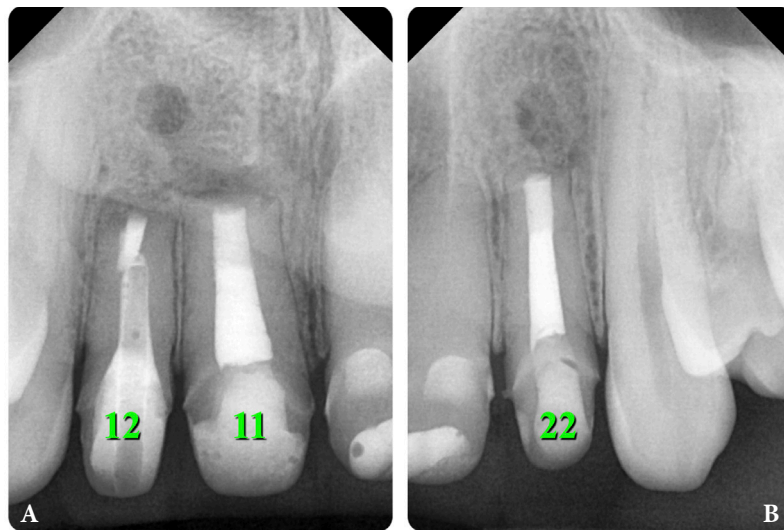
X-ray (A, B) and CBCT (Fig 30B) after 1 year and 6 months show signs of incomplete healing (according to Rud and colleagues (1972) [20] and Molven and colleagues (1987) [21] classification) in the area of teeth 11, 12, and 22. It is worth noting that incomplete healing in endodontic microsurgery is evaluated as success [22]. 12, upper right lateral incisor; 11, upper right central incisor; 22, upper left lateral incisor.
